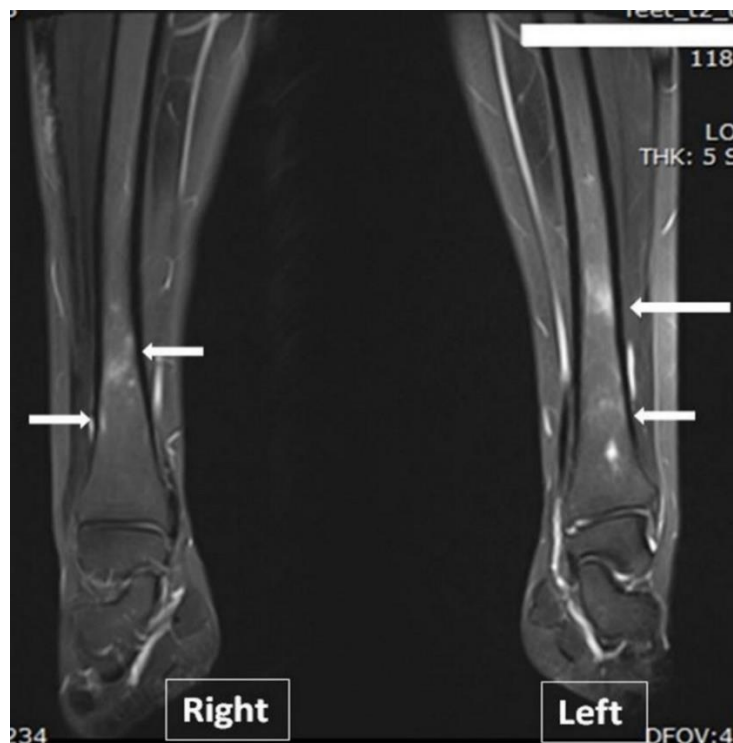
Final MRI Results
